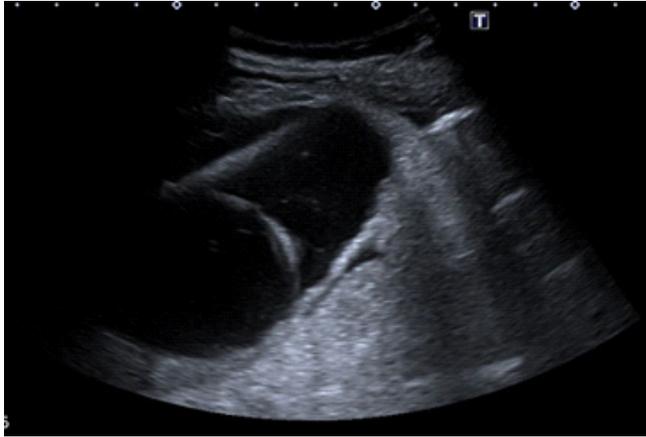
Grey scale ultrasound images shows the adequate placement of cholecystostomy drainage catheter within the gall bladder.
